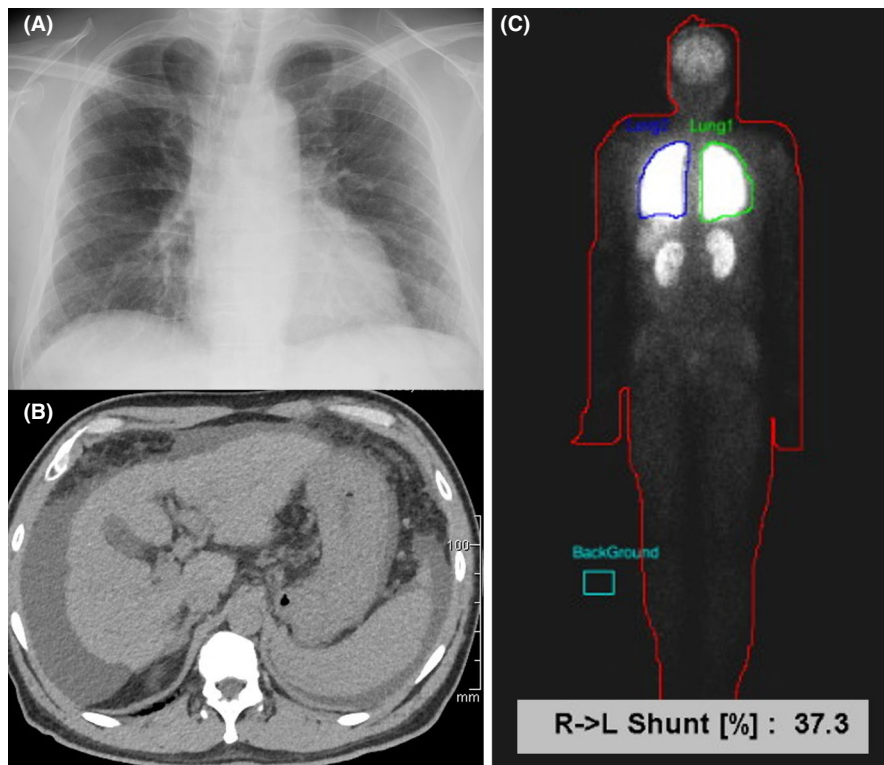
Chest radiography revealing bilateral diffuse interstitial opacities (A). Total lung capacity, residual volume, and forced vital capacity are within normal range, and % DLCO is decreased to 30.8%. Computed tomography revealing liver atrophy, surface irregularities, splenomegaly, and ascites (B). Lung perfusion scintigraphy with ^{99m}Tc -MAA revealing accumulation in the brain, kidneys, and gastrointestinal tract (shunt=37.3%) (C). Defects in ^{99m}Tc -MAA are absent in the lungs. Home oxygen therapy is initiated, and liver transplantation is currently under consideration
